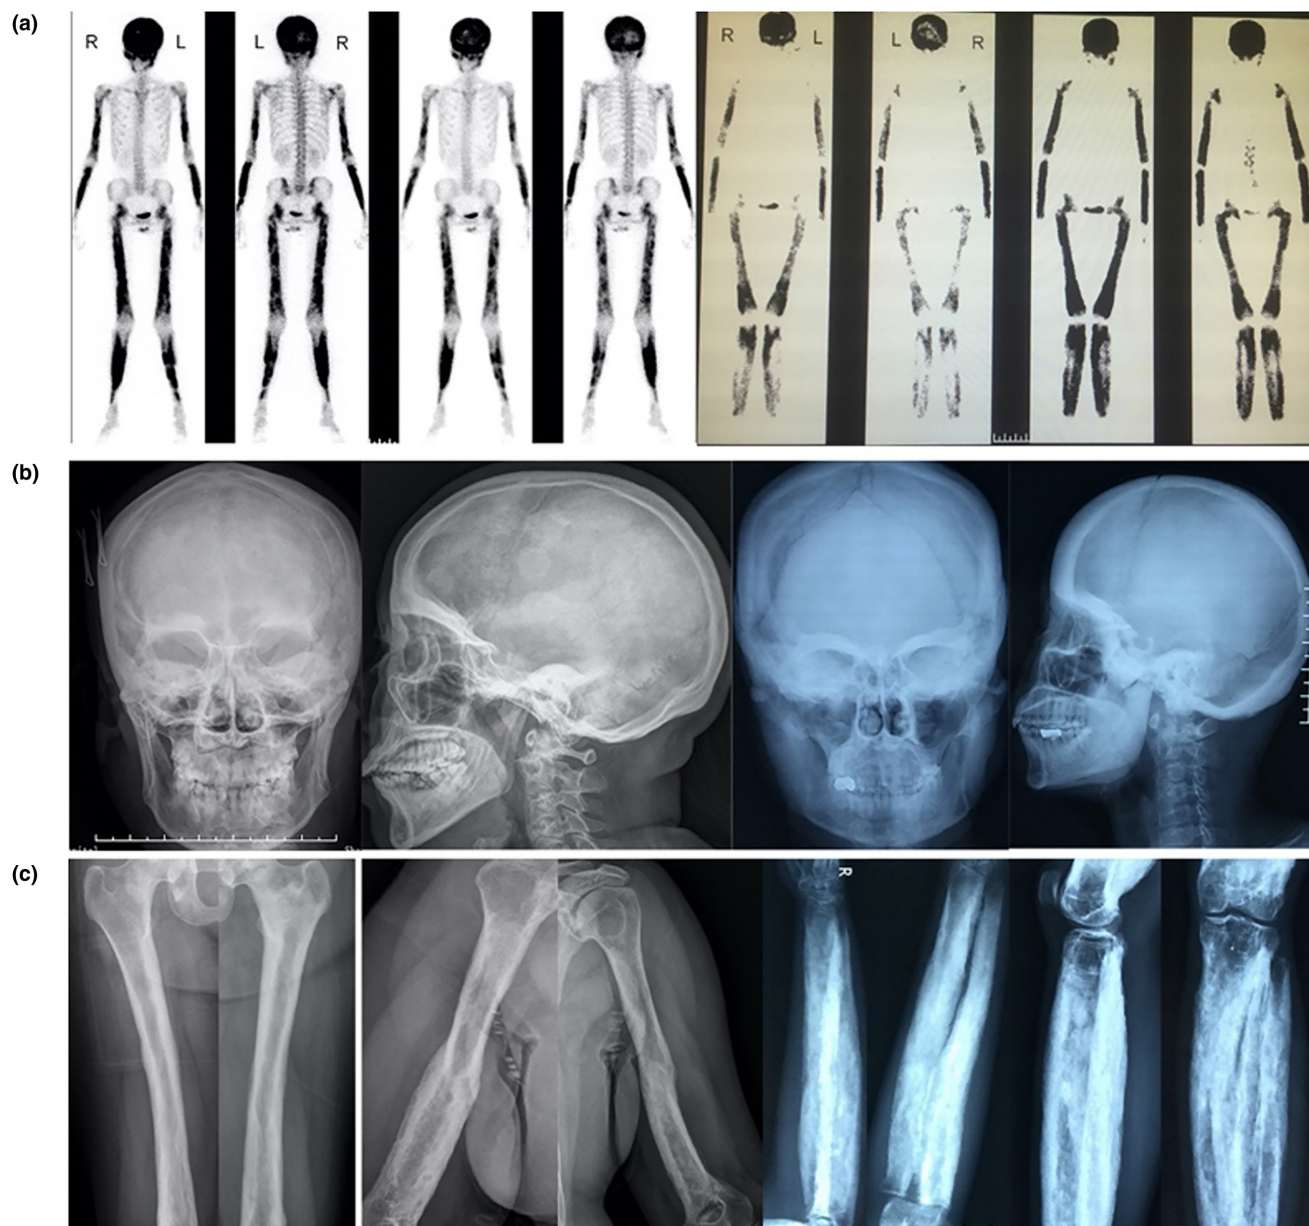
Typical radiographic manifestations of CAEND patients. The imaging findings of proband 1 (22 years, woman) and proband 2 (34 years, woman) were shown on the left and right, respectively. (a) Bone scintigraphy with ^{99m}Tc -methylene diphosphonate showed a marked symmetrical increase in radioactivity at the limbs and skull; (b) X rays revealed uneven or significantly increased bone mineral density of cranial bones, along with the thickened diploic bone and sclerosis of the skull; (c) X rays showed periosteal and endosteal thickening of the diaphyseal of the long bones, as well as the enlarged tubular bone diaphysis of extremities and narrowed medullary cavity
